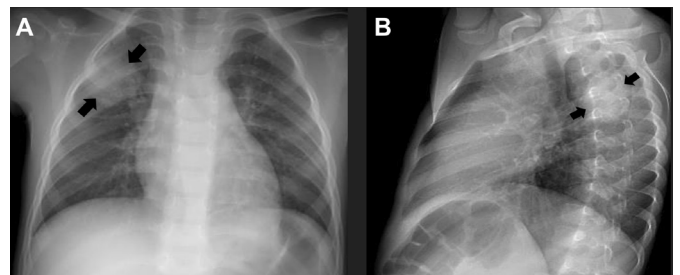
A 3-year-old boy with fever. Posterioranterior (A) and lateral chest radiographs (B) show well-defined, 4-cm round pneumonia in the right upper-lobe (arrows).
